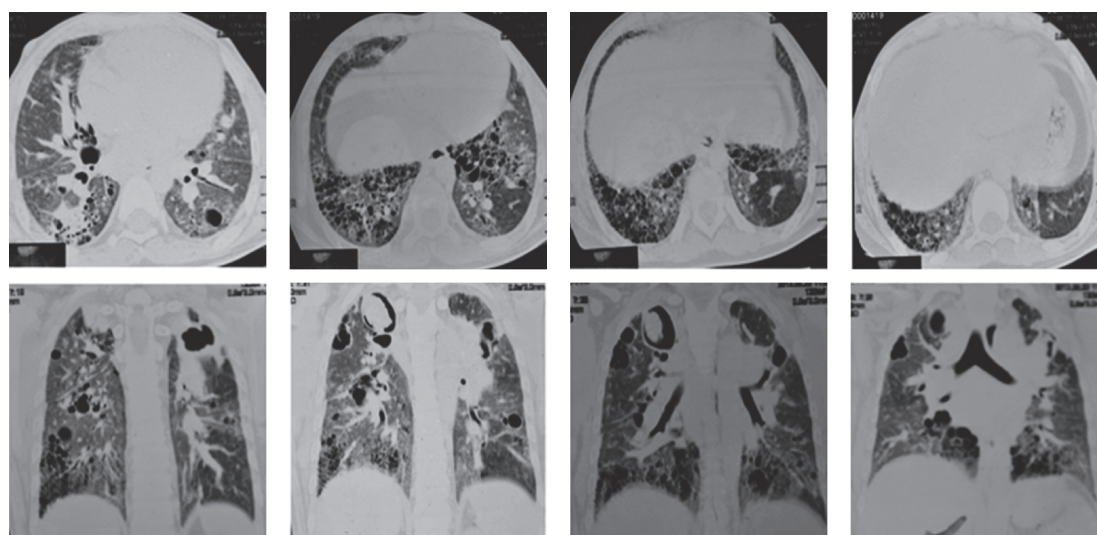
A 12-year-old female patient. A. HRCT image shows diffused ground glass opacities in bilateral lung fields with multiple cystic bronchiectasis. Well encapsulated cavitory lesion with dense nodules suggestive of fungal ball involving in right upper lobe also seen.
